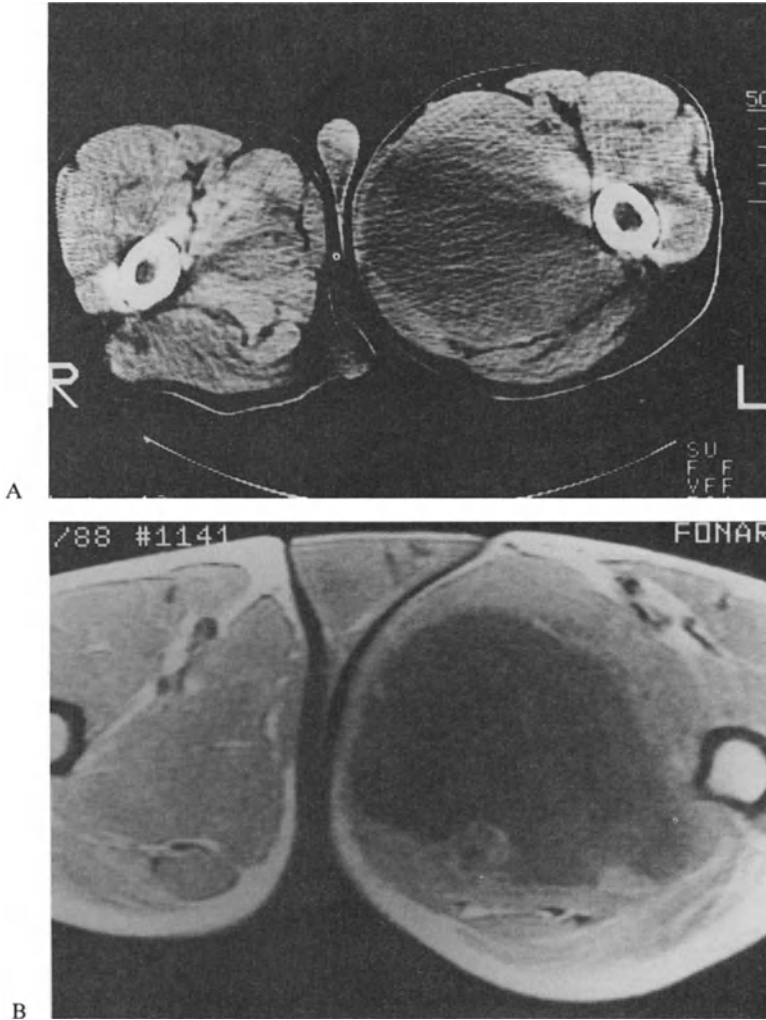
Internal structure and local extent using CT and MRI: malignant fibrous histiocytoma, left adductor magnus muscle in axial view. A: CT examination through the vertex of the lesion without contrast enhancement. A rather poorly defined soft tissue mass is seen in the compartment of the adductor muscles. Streak artifacts are caused by the dense cortical bone. B: T1-weighted spin-echo sequence, at the same level. A tumor capsule with irregular excrescences is seen peripheral to a homogenous mass representing a hematoma. The outline of the internal structure of the mass allows for an optimal choice of the biopsy site.
